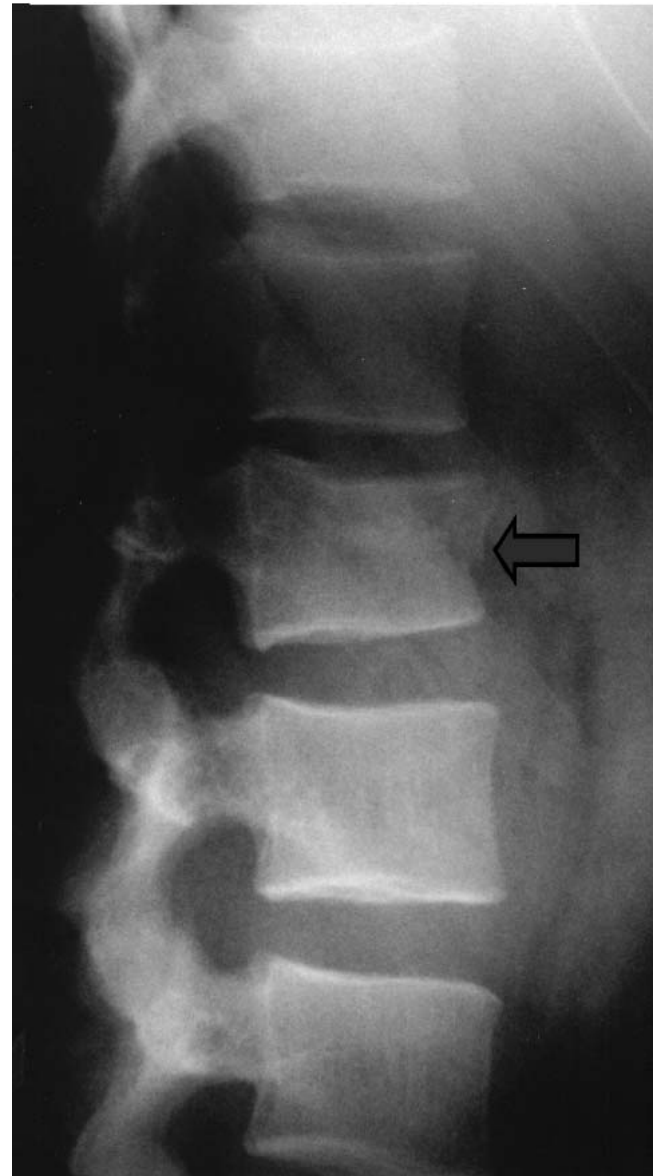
Lateral spine X-ray demonstrating a compression fracture.
